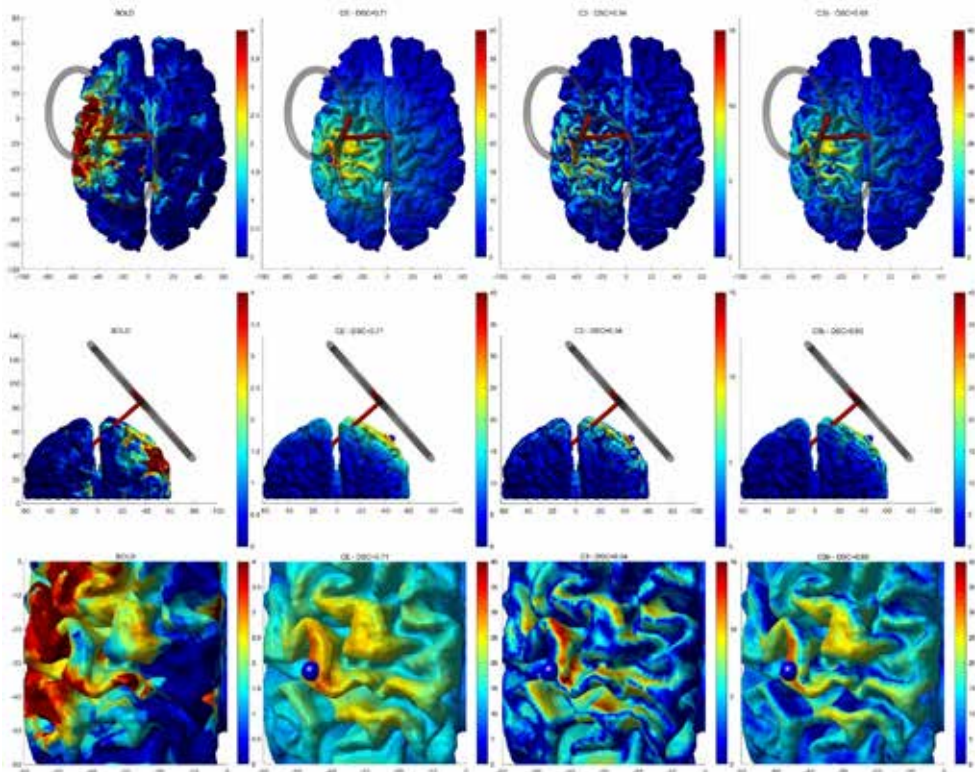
Cortical renderings of TMS evoked BOLD activation (left panels) and modeled activation for the CE, C3 and C2 metrics (from left to right). In the title, the DSC overlap coefficient between measured BOLD and modeled activation is given for each metric. Top panels and middle panels provide a top and middle view of the entire cortex, with an idealized TMS coil rendered at the reconstructed TMS coil position (from the T2 weighted MRI, see methods) and coil B-field isocenter. The bottom panels provide a zoomed-in version of the same data. The blue sphere was the center of the ROI for which the analytical comparison between observed activation (left panels) and the model activations (other panels) was computed.
